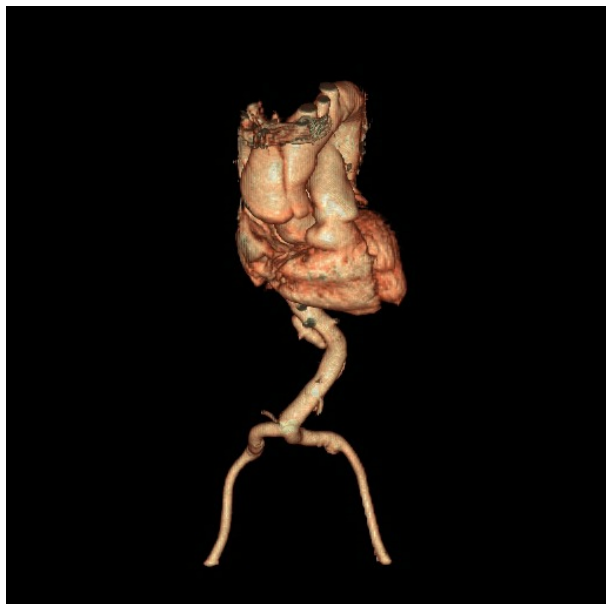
Saccular aneurysm of the ascending aorta as seen from computed tomography reconstruction
